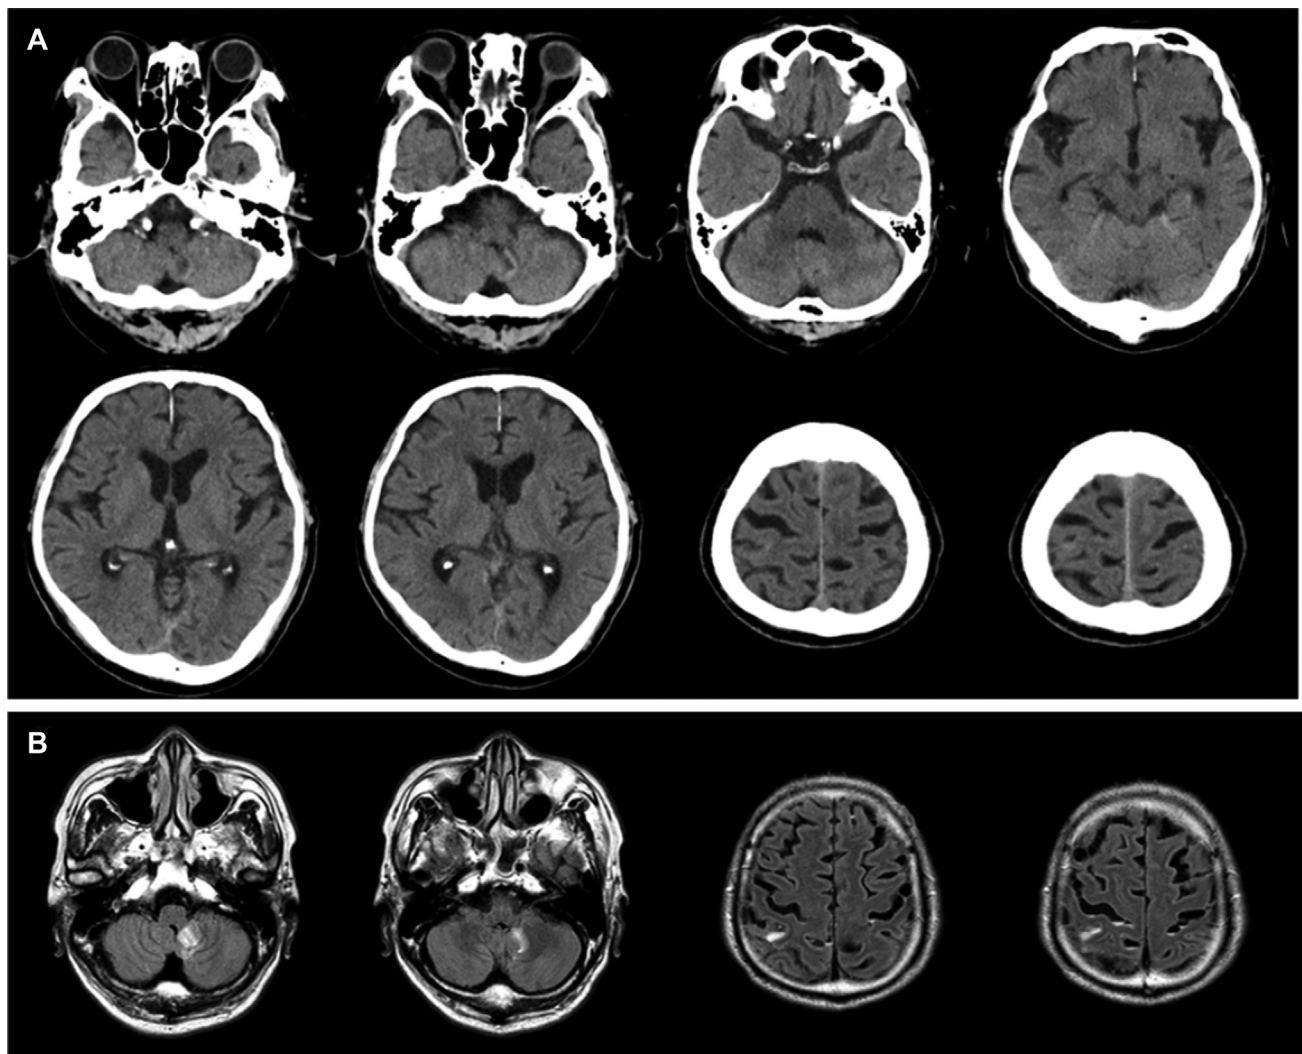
Head computed tomography (A) and magnetic resonance imaging fluid attenuated inversion recovery (B) showing a small amount of subarachnoid hemorrhage in both cerebral hemispheres and a subacute ischemic area in the medial left cerebellar hemisphere.
